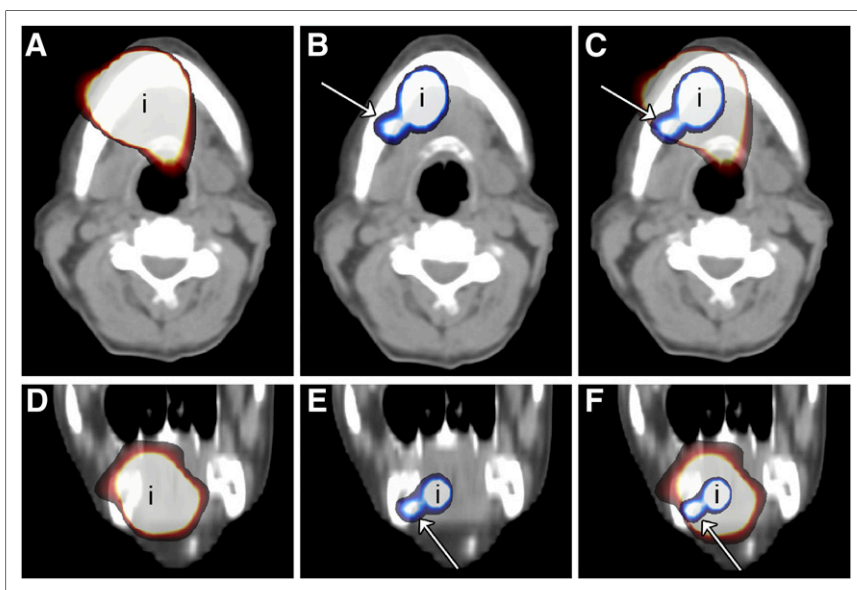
(A and D) Transversal (A) and coronal (D) SPECT/CT image of injection site (i) of patient 1, i.e., floor of mouth, in which only a large hot spot from injection site could be visualized. (B and E) PET/CT image of injection site of same patient in which level IB lymph node (arrow) clearly could be identified. (C and F) Fused SPECT and PET/CT images showing that lymph node visualized on PET/CT is hidden behind large hot spot on SPECT/CT images.
